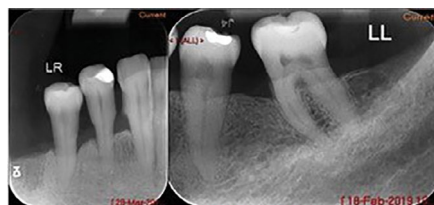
Periapical radiographs from 2019 showing LR and LL posterior teeth
